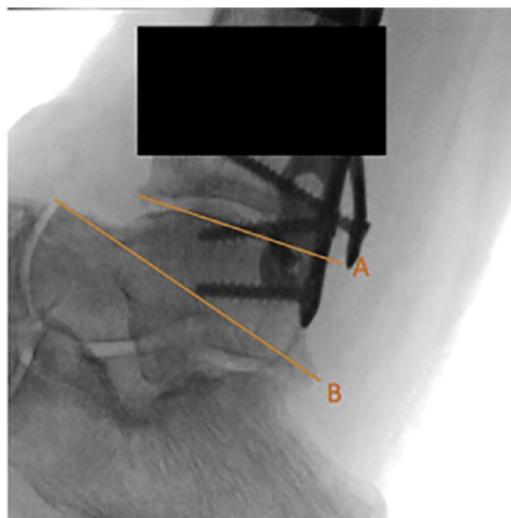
Example of lateral ankle radiograph edited to blind syndesmotom screw presence (black box) with reference lines for angle measurement. The tibial reference line connects the 2 most distal points on the anterior and posterior tibial plafond (A). The talus reference line connects the points between the posterior process (lateral tubercle) of the talus and the anterodorsal aspect of the talus head (B). (From Briceno J, Wusu T, Kaiser P, et al. Effect of Syndesmotom Implant Removal on Dorsiflexion. *Foot Ankle Int.* 2019;40(5):499-505. <https://doi.org/10.1177/1071100718818572>; with permission.)
